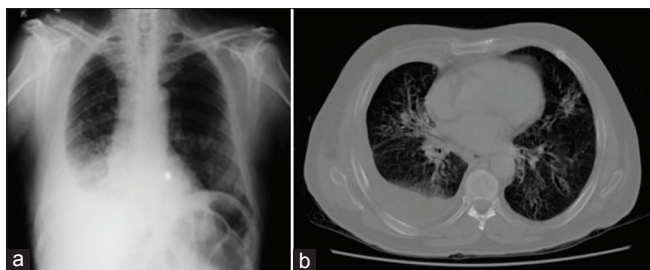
(a) Chest radiogram showing right lower zone consolidation with pleural effusion; (b) CT thorax (lung window) showing tree-in-bud appearance with right basal consolidation and pleural effusion
